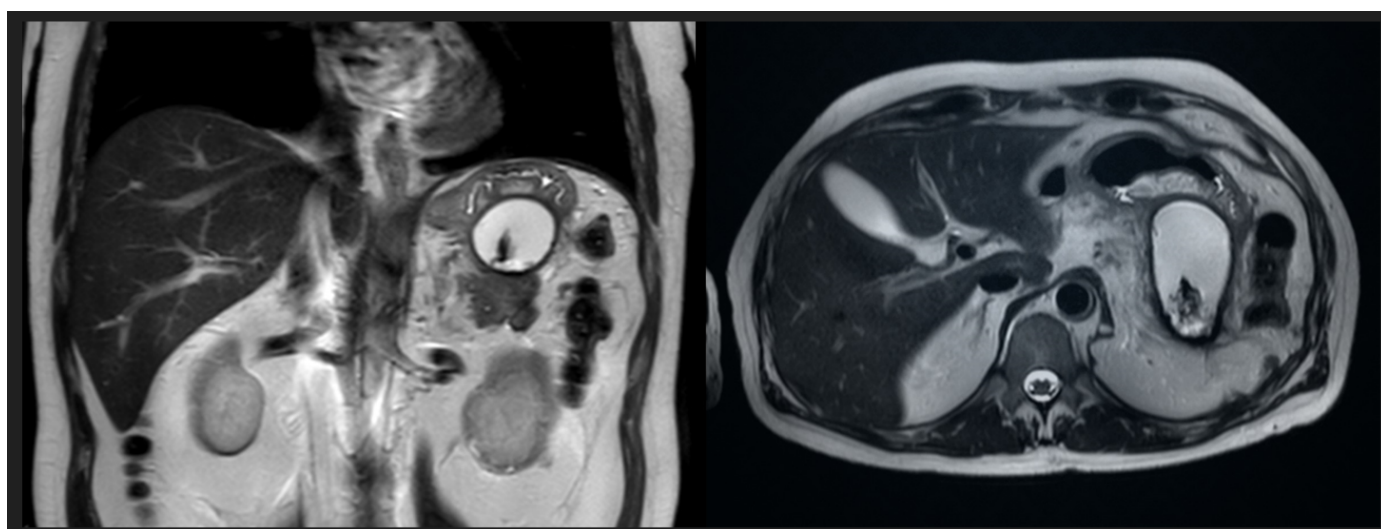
MRI examination from March 2017
